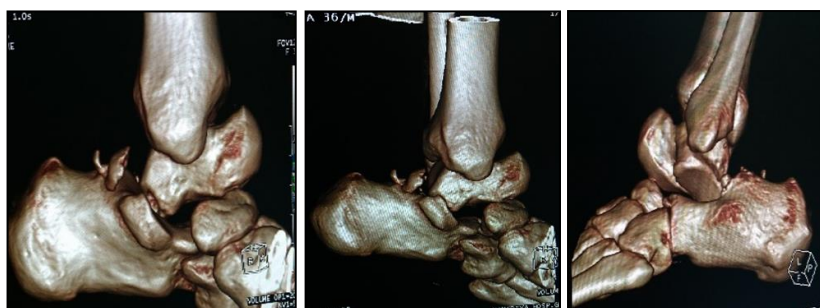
3D reconstruction of CT Scan of ankle joint of a 40-year-old male showing the talocalcaneonavicular dislocation associated with fracture of posterior process of talus with chip fracture of the calcaneum and subluxation of tibiotalar joint.
